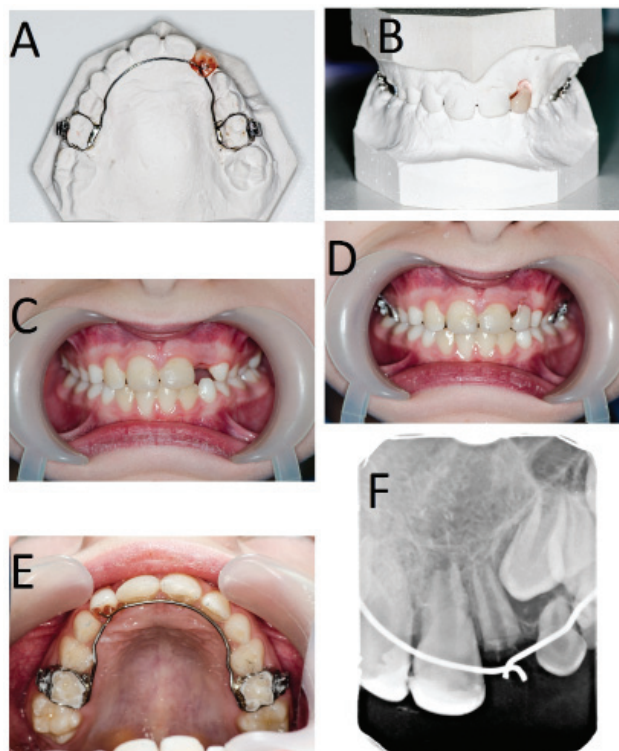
A, B – upper lingual arch with acrylic tooth #22 on the dental cast. Orthodontic bands fitted on the upper second deciduous molars. C – up-front view of patient's anterior dentition without the prepared appliance. D, E – patient's dentition with the cemented lingual arch: up-front (D) and palatal view (E). F – dental radiograph taken after the placement of orthodontic appliance – 4 weeks after the trauma
